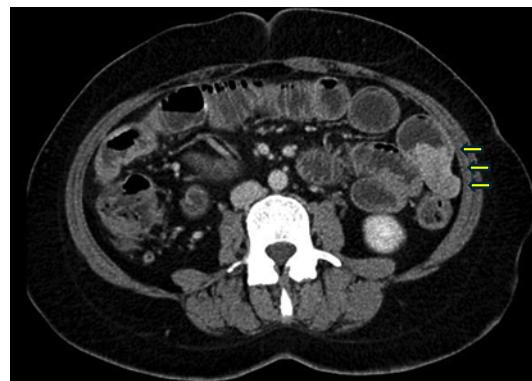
Axial computed tomography image of an enhancing proximal jejunal submucosal tumour. The arrows show the location of the lesion.
